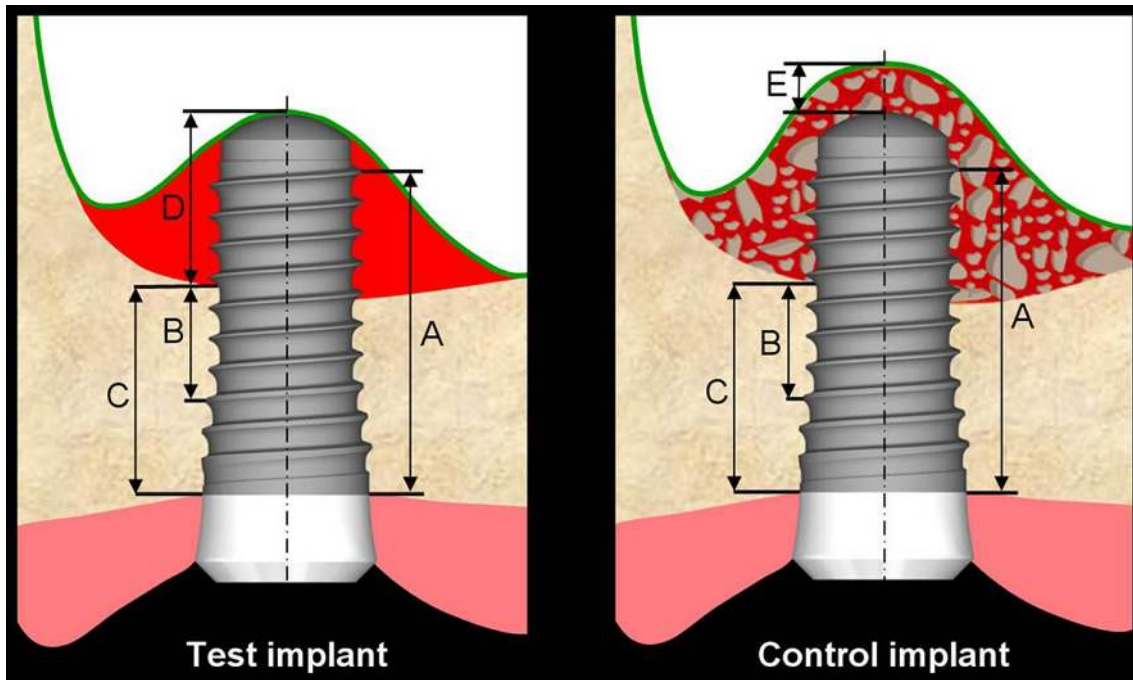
Radiographic measurements.
